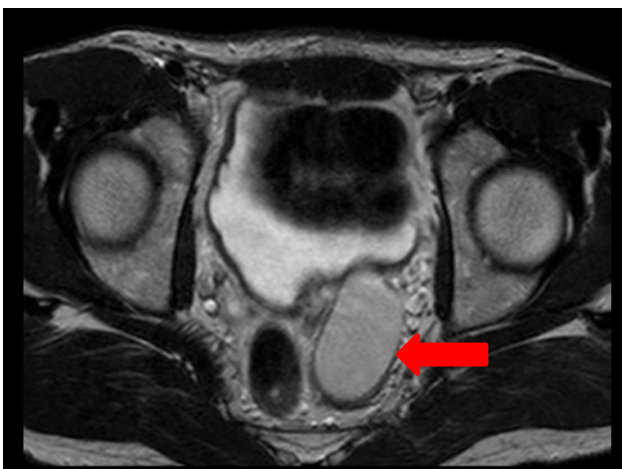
Axial section of MRI pelvis of the patient showing cystic dilatation of left seminal vesicle with moderate hyperintensity on T2W imaging (marked in red arrow).
